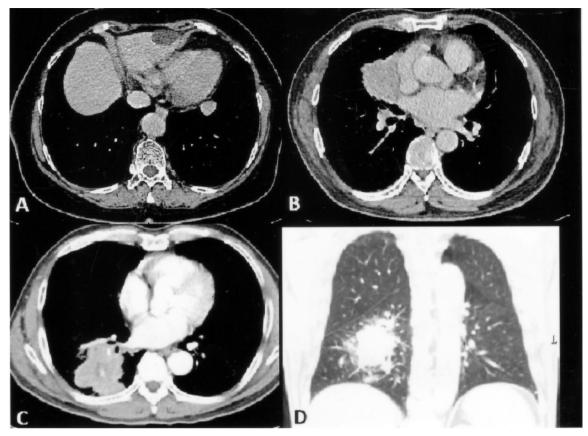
The typical CT characteristics of primary pulmonary LELC are a centrally located tumor, 1.8-6.6 cm in size (Figure 1A-C). (A) Small, well-defined, centrally located nodule in the left lower lung, without pericardial invasion. (B) Centrally located tumor with irregular border and obvious pericardium invasion. (C, D) One of the centrally located tumors had central necrosis with vascular encasement.
